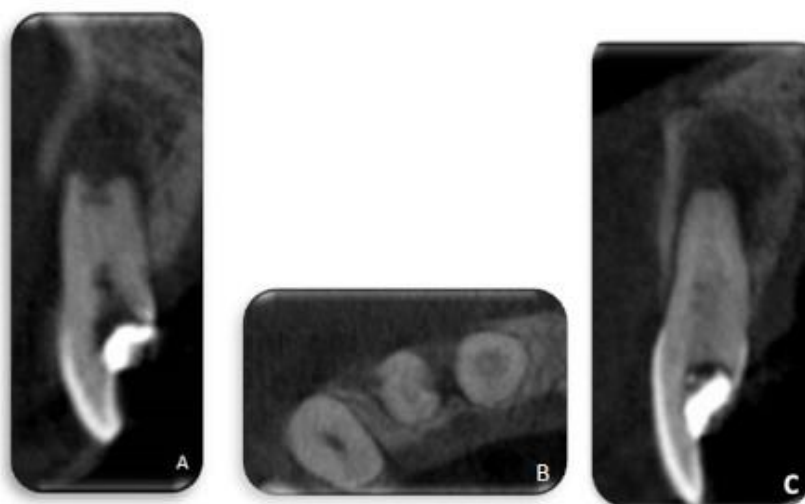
Cone beam computed tomography scans of the maxillary anterior teeth 11 and 12; (A): Sagittal cross section showing open apex in tooth 12 and the extensive involvement of the buccal cortical plate. (B): Axial CBCT scans shows that the resorptive defect has perforated the root canal walls of tooth 12 (the distal and mesial aspect). The radiolucent lesion has perforated the buccal cortical plate in relation with tooth 12. (C): Axial CBCT scans showing a radiolucent defect in the middle third of root canal of tooth 11 and an apical root resorption associated to a periapical radiolucent lesion
